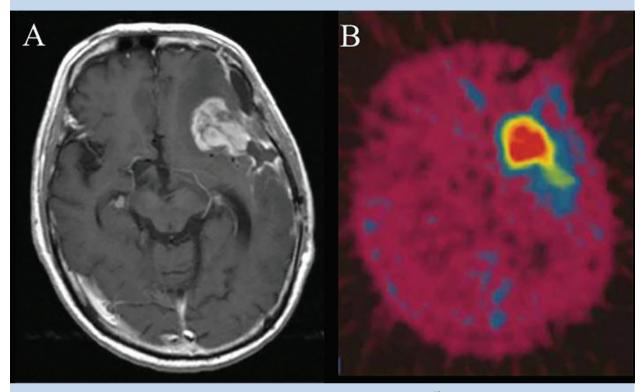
Contrast-enhanced T1-weighted MRI of a representative glioblastoma patient and ¹⁸F-labeled BPA-PET image after initial debulking surgery
